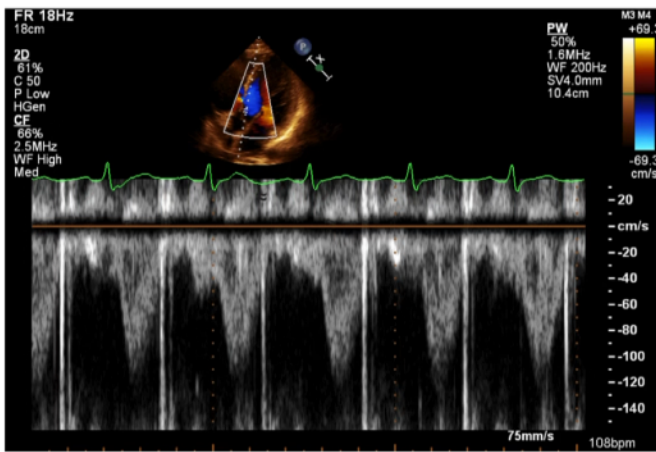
Pulsed-wave Doppler measurement of LVOT velocity-time integral demonstrating stroke volume calculation.
